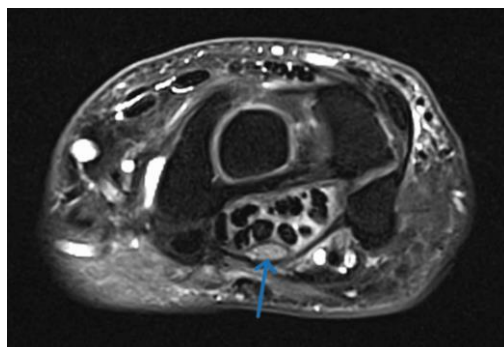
Axial T2-weighted fat-suppressed image shows median nerve (arrow) within the carpal tunnel is enlarged and shows increased T2 signal intensity, consistent with neural edema secondary to compressive neuropathy.
